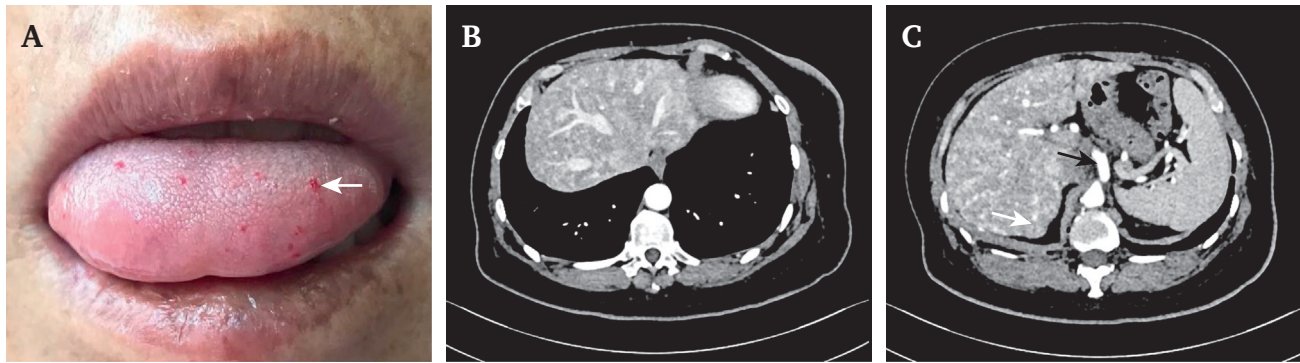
(A) Multiple telangiectasias were located on the tongue mucosa (white arrow). (B) Contrast computed tomography (CT) showed that the hepatic vein was enhanced earlier during the arterial phase. (C) CT showed dilated and tortuous hepatic arteries (black arrow), splenomegaly and multiple hyperplastic nodules (white arrow), indicating the existence of portal hypertension.
